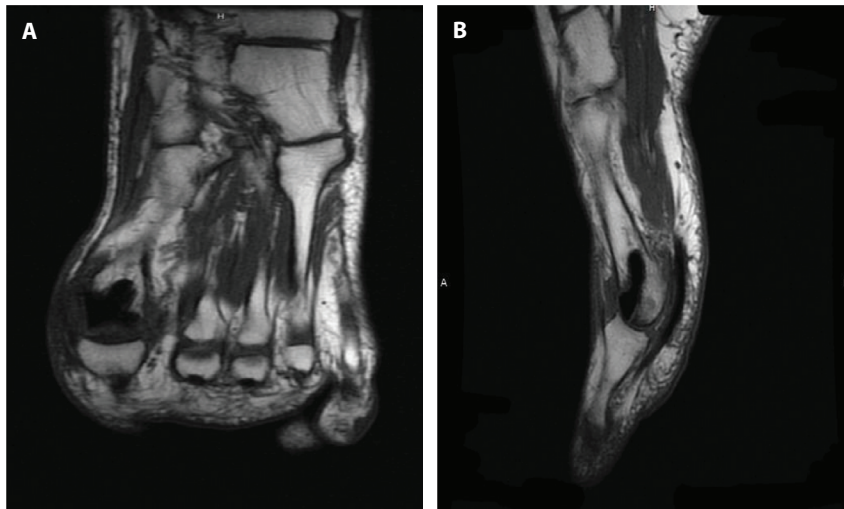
Left foot MRI (a: anteroposterior view; b: lateral view).
